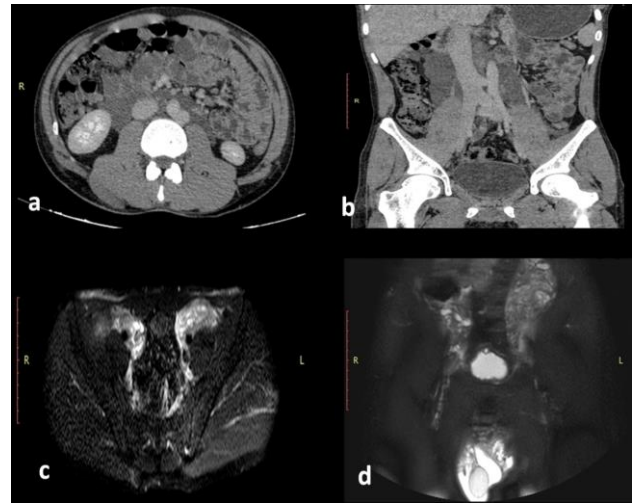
(a) CT scan of abdomen and pelvis in venous phase, shows nonenhancing retroperitoneal cystic lesion in pre and paraaortic region in axial (b) and coronal reconstruction. (c) MRI of abdomen and pelvis in axial reconstruction showing T2/STIR hyperintense multiple dilated cystic lesions in pelvis (d) in axial reconstruction and in retroperitoneum and scrotum in coronal reconstruction.
